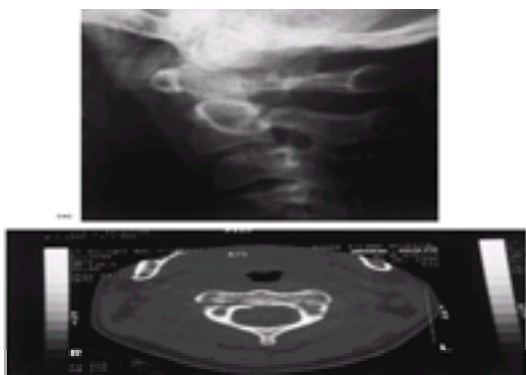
(a) Lateral radiograph showing fractured C2; (b) CT scan more clearly demonstrating fracture pattern of the axis, type II. Fracture subluxation C4, C5, the result of flexion–distraction mechanism of injury.
